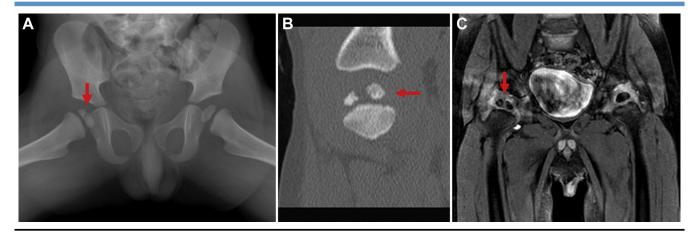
Epiphyseal cleft. A, On the hip radiograph, a radiolucent cleft (*red arrow*) divides into an irregular and flattened epiphyseal nucleus of the proximal femur. B, Computed tomography scan demonstrates a double epiphyseal nucleus (*red arrow*) without periosteal reaction, cortical disruption, or lytic lesion. C, Coronal MRI scan does not show any alteration of signal intensity (*red arrow*).
